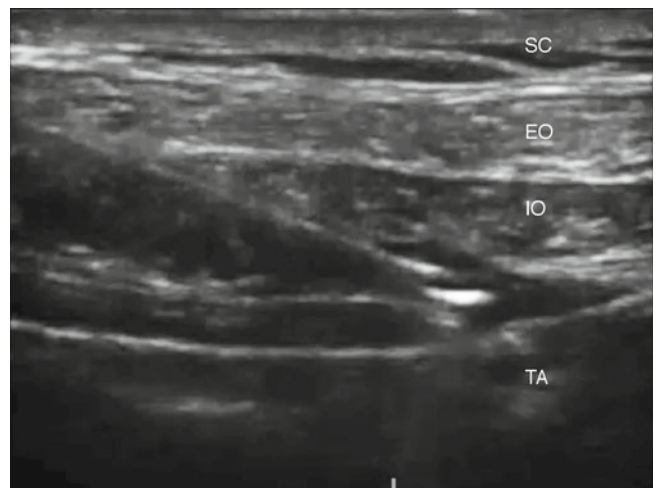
Endpoint for TAP block under ultrasound guidance. Subcutaneous tissue (SC), external oblique (EO), internal oblique (IO), transversus abdominis (TA). Note hydrodissection around needle tip
